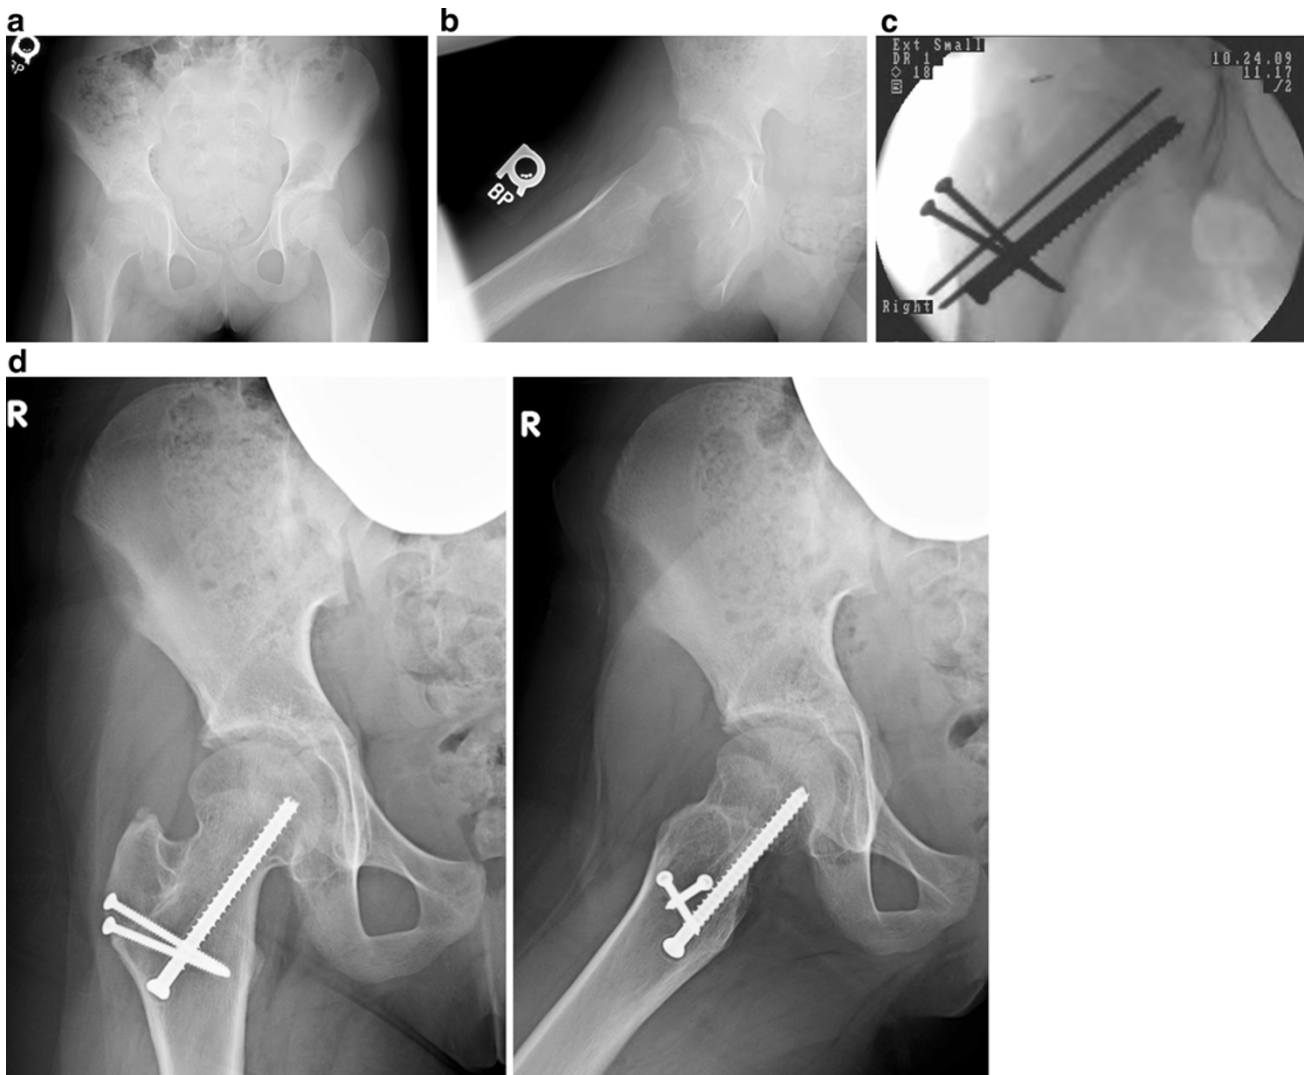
a, b AP and frog view in a teenage female with acute, unstable, right SCFE. c Intraoperative radiograph after modified Dunn open surgical dislocation, femoral neck shortening, and recentering of the femoral head on the femoral neck (Ganz method). d AP and frog
